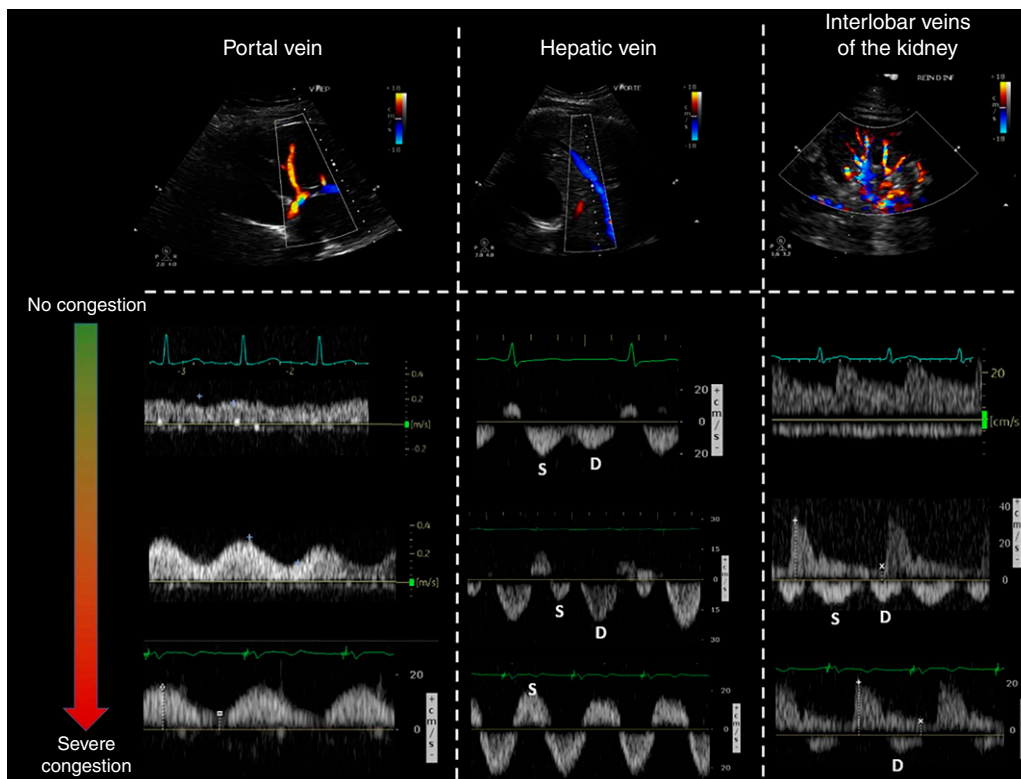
Venous Doppler patterns with worsening venous congestion. Portal vein Doppler exhibits increased pulsatility as venous pressure increases. In the hepatic vein, the systolic (S) component of venous return decrease and disappear or become retrograde with severe elevation in right atrial pressure. In the interlobar veins of the kidney, interruptions in the venous Doppler signal become prolonged as the venous systolic component disappear. D, diastolic.
